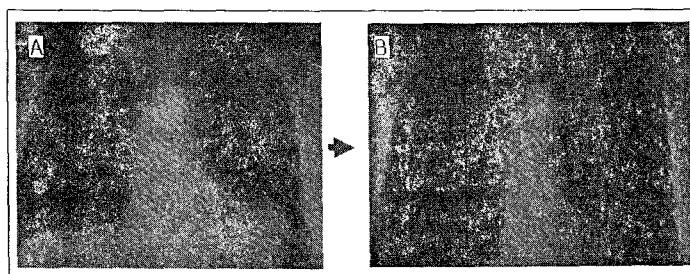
Chest radiograph images
